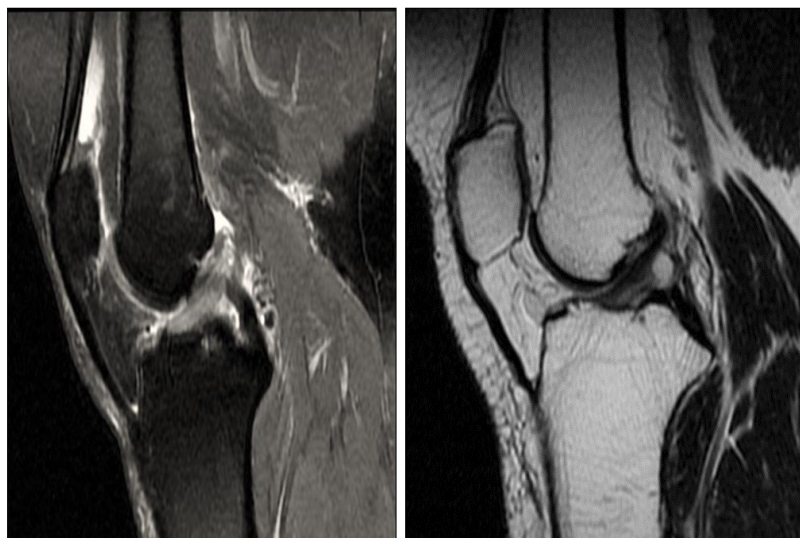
ACL mucoid degeneration in PD weighted and T2 weighted sagittal MRI images
